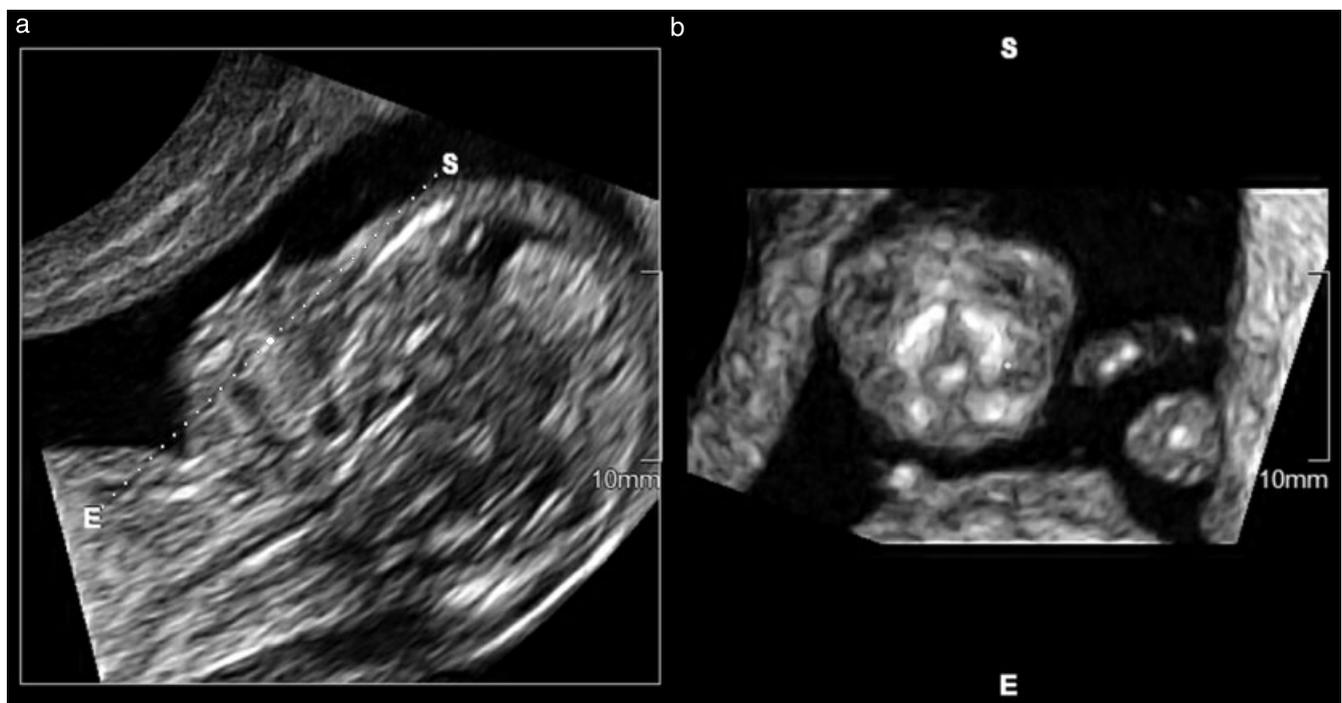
Transabdominal sonography in a first-trimester fetus with holoprosencephaly and cleft palate. The mid-sagittal view shows the fetal profile (a). The oblique view technique shows the simultaneous coronal plane (b) at the level of the reference line (dotted line in (a)). Note the abnormal configuration of the retronasal triangle. E, end point; S, start point.
